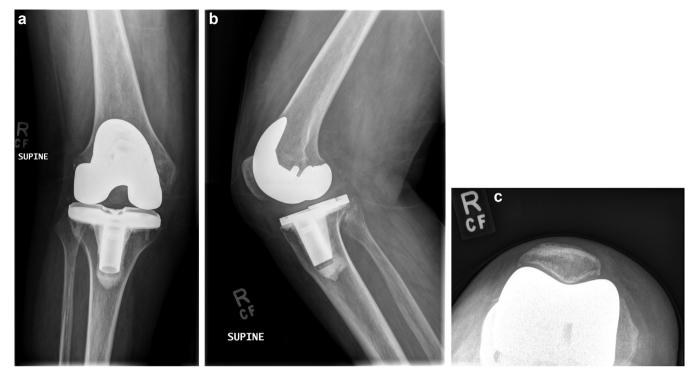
Postoperative (a) anteroposterior, (b) lateral, and (c) Merchant radiographs.
